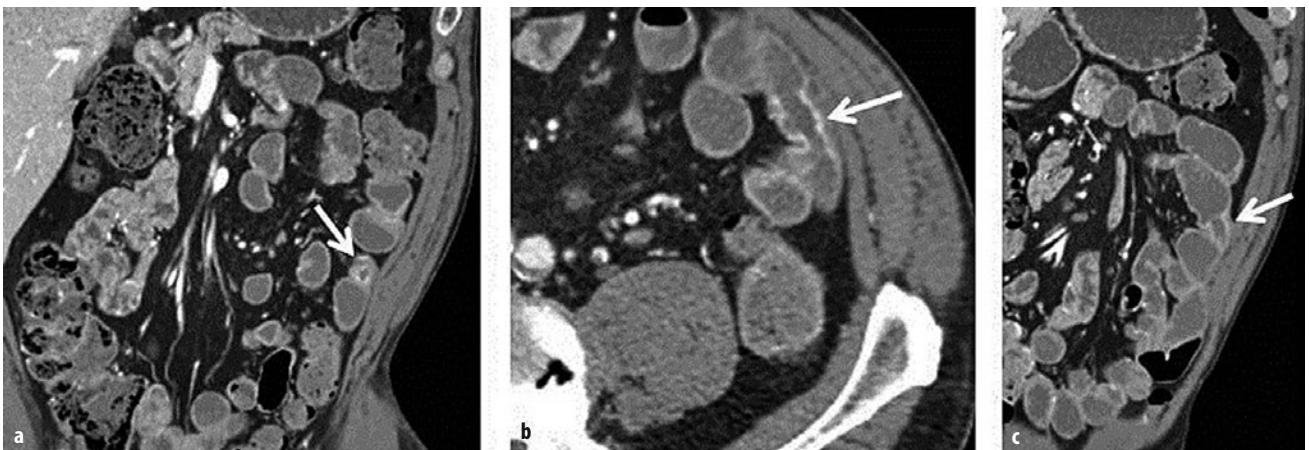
a-c. A 69-year-old man with obscure gastrointestinal (GI) bleeding. a Coronal and b axial images from enteric phase of a multi-phase computed tomography (CT) enterography demonstrate a 1.5-cm stricture with symmetric enhancement in the proximal ileum (a, b arrows). Three other similar-appearing, short-segment strictures are seen nearby (one shown in c, arrow). Subsequent antegrade balloon-endoscopy demonstrated mid-ileal strictures with ulcerated rims, consistent with nonsteroidal anti-inflammatory drug (NSAID)-induced diaphragm disease
